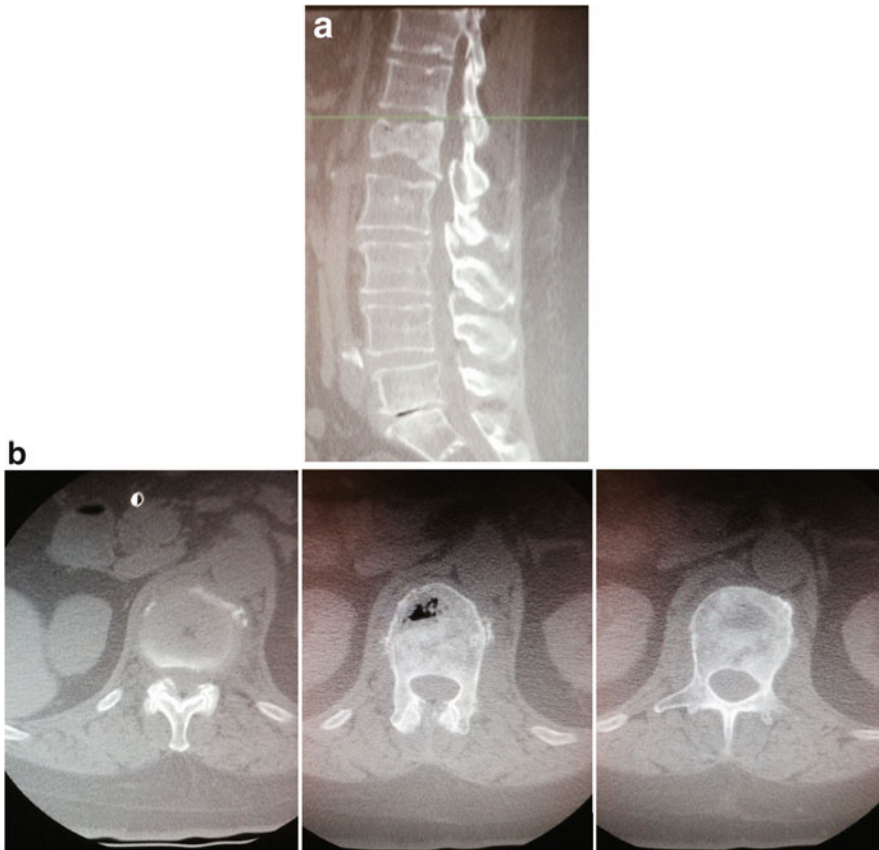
Sagittal (a) and axial (b) computed tomography images of a L1 compression fracture secondary to metastatic colon cancer. No retropulsion of fracture fragments
